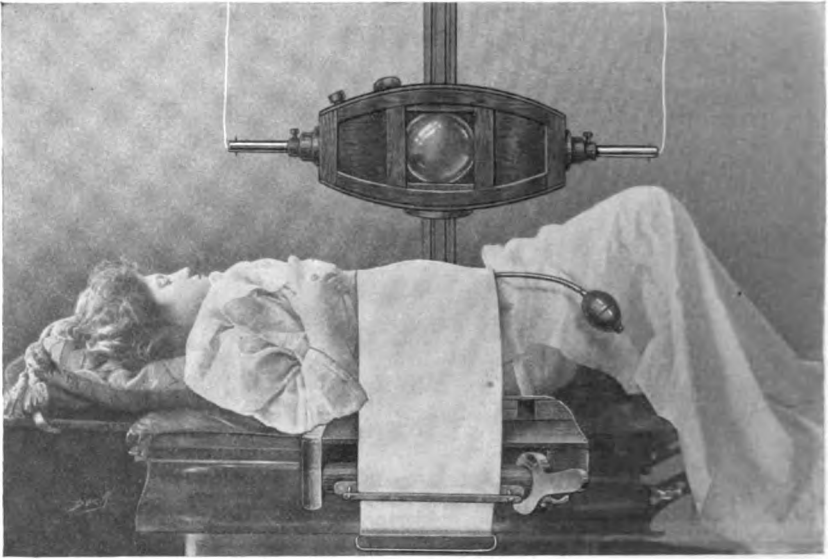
Renal radiography with compression band, under which is an inflated rubber bag. The author's plate tunnel enables one to put the plate in exactly the right place without moving the patient and to change it for stereoscopy.
